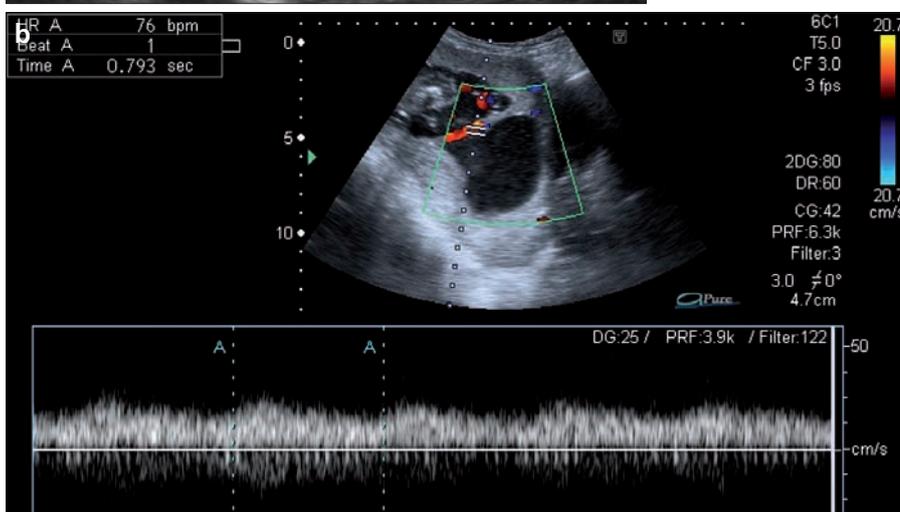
A color Doppler US of the patient no. 6 and spectral analysis of the amniotic sheet showing a non-pulsatile venous flow.
